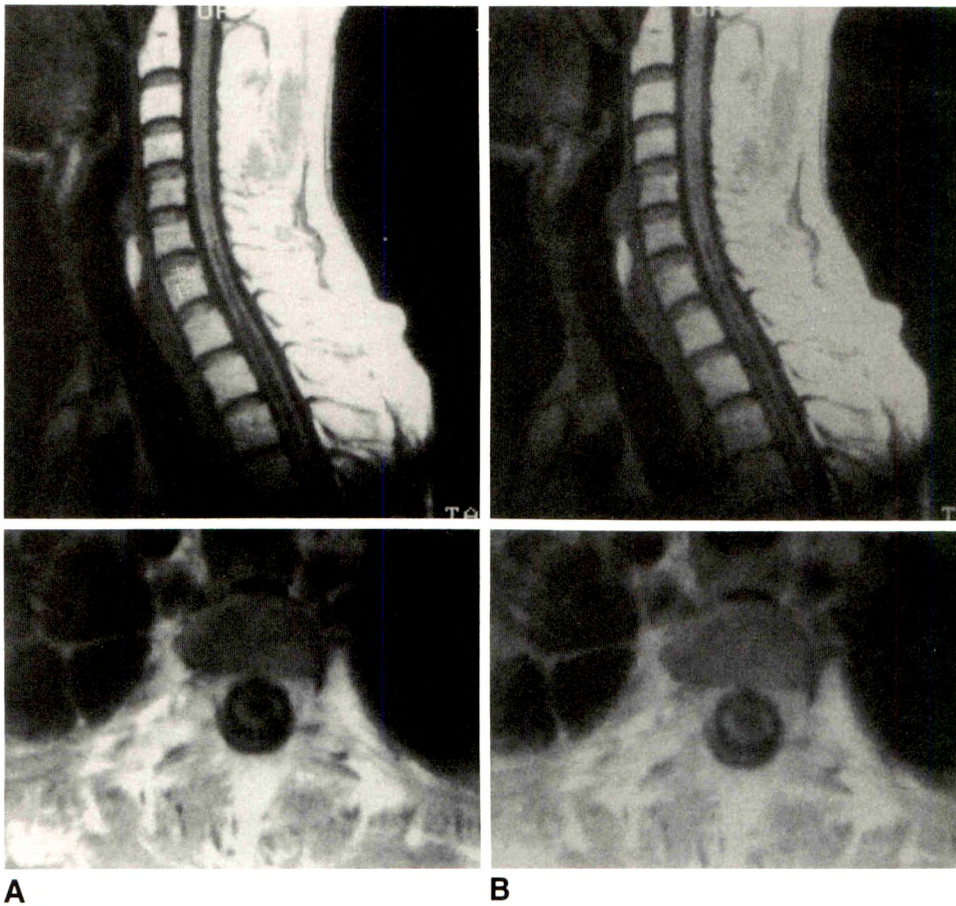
A, Original MR images of 21-year-old man with syrinx in lower cervical and upper thoracic spinal cord. B, Teleradiology hard copy of A. Black is less black and white is less white than on original. Image detail is still good.
